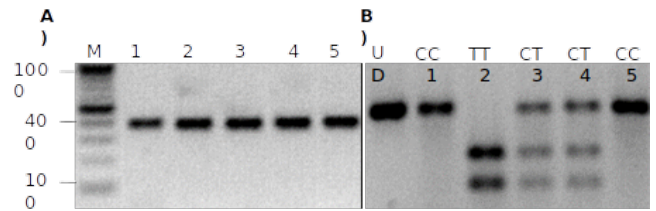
2 % agarose gel images of PCR-RFLP reactions of *MTHFR*. A) PCR products used for the RFLP reaction; B) RFLP results of TaqI digestion reactions. CC: homozygous reference, TT: homozygous mutant, CT: heterozygous mutant, M: Marker (bp) and UD: Undigested PCR product.
